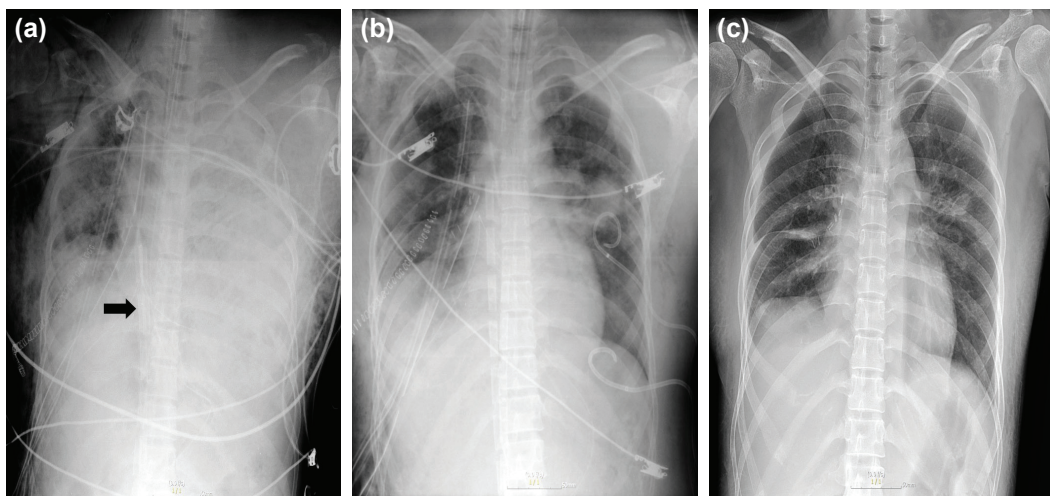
Immediate postoperative simple chest radiography shows venous catheters (black arrow) for extracorporeal membrane oxygenation (a). Simple chest radiography shows improvement on postoperative day 4 (b) and at the time of patient discharge (c).
